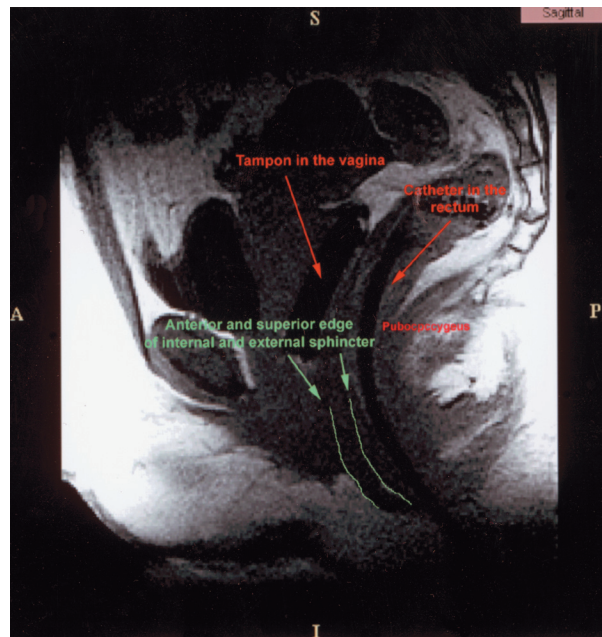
Reconstructed internal and external sphincter seen on the sagittal MRI image of the pelvis and abdomen.
